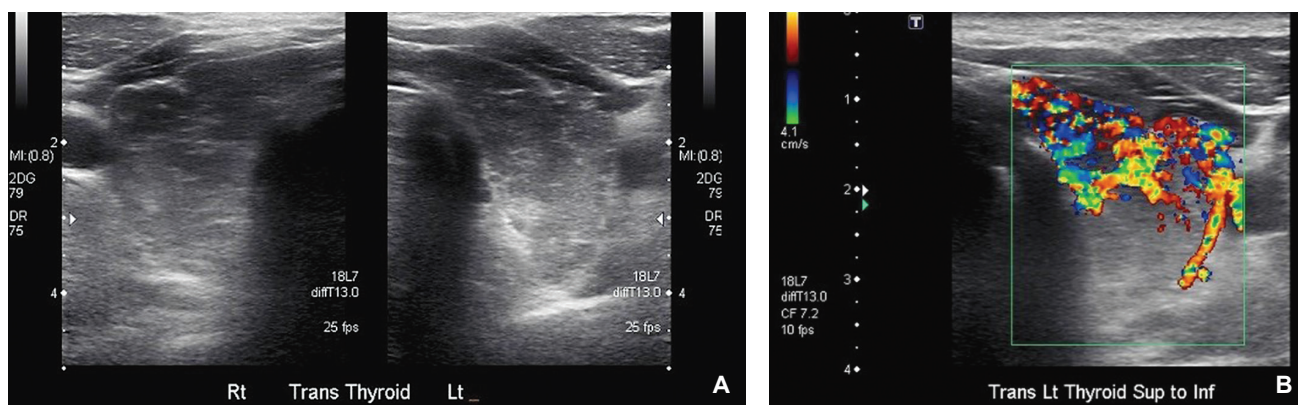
Ultrasound of the thyroid gland showing heterogenous echogenicity of the tissue parenchyma (A) and increased vascularity (B).
